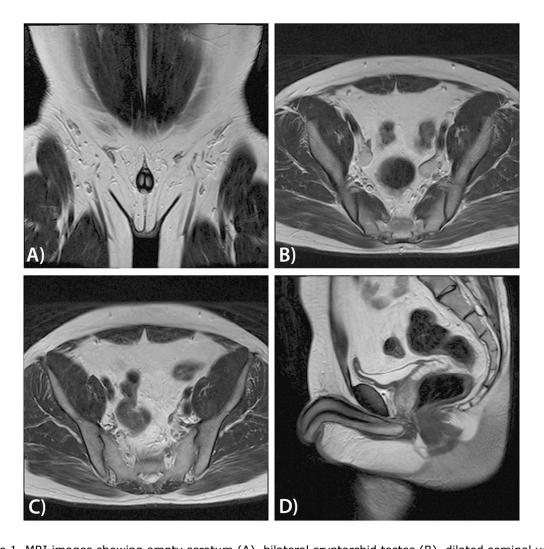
MRI images showing empty scrotum (A), bilateral cryptorchid testes (B), dilated seminal vesicle (C) and a micro-penis (D).
